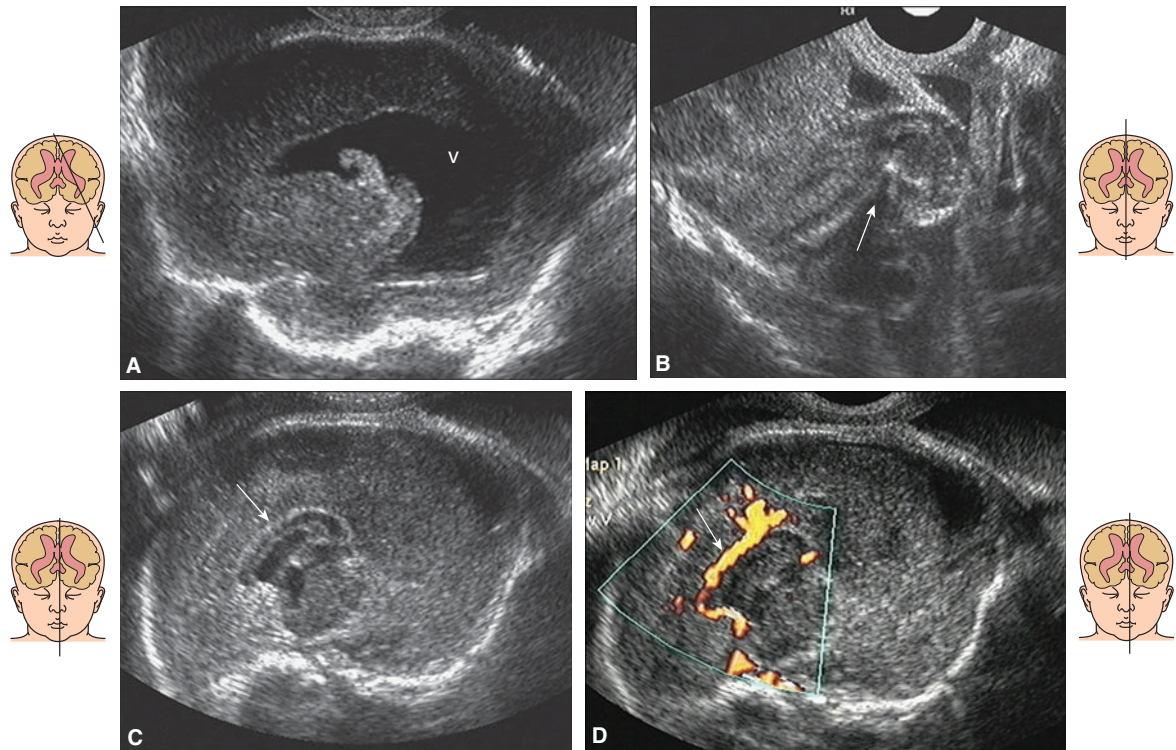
A 34-week fetus with Walker-Warburg syndrome. (A) An oblique section was obtained using transvaginal sonography, which demonstrates the dilated lateral ventricles, V. (B) The posterior encephalocele is seen protruding through the skull defect (arrow). (C), (D) Median section of the fetal brain showing the corpus callosum (arrow) and the pericallosal artery (two arrows). The brain surface is very smooth, and there is an absence of the cingulate gyrus that is consistent with lissencephaly.
